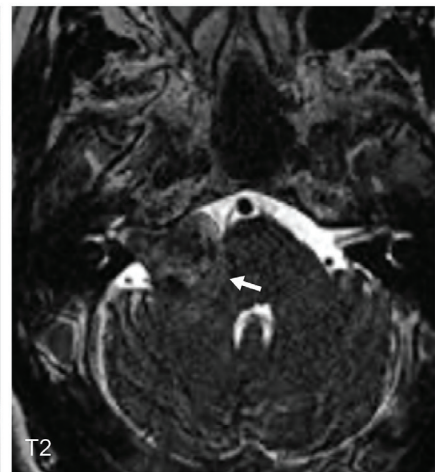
(A) Initial MRI showed a right CPA lesion (*white arrows*) with low T1 signal, heterogenous high T2 signal and diffuse enhancement extending into the *porus acusticus*, occupying the right internal auditory canal. (B) Pre-SRS imaging showed increased lesion size (*white arrow*) with mass effect over the brainstem, causing effacement of the fourth ventricle (*white asterisk*) and mild supratentorial hydrocephalus (*blue arrowheads show enlargement of the trigones of the lateral ventricles and surrounding transependymal edema, features consistent with obstructive hydrocephalus*). (C) MRI 5 years post-SRS confirmed tumor stability (*white arrow*).
